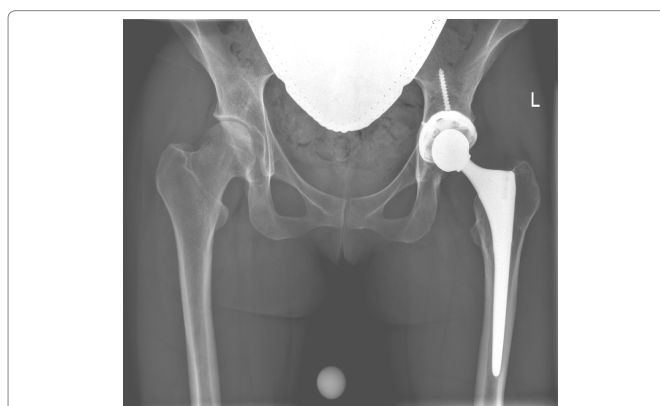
Case 1: Post-revision radiograph demonstrating correct implant positioning with no signs of impingement and a stable notch size.
